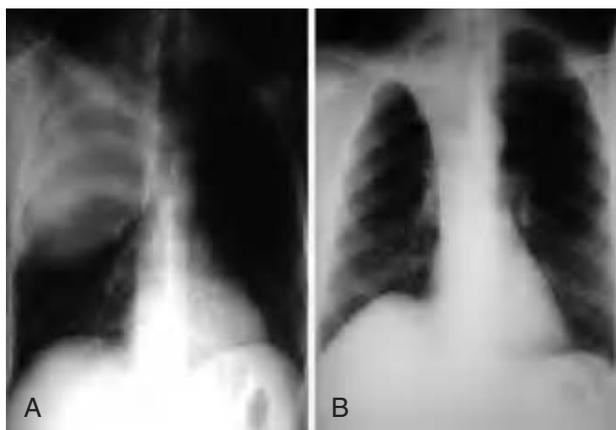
Chest radiograph showing a 15 cm mass (A) and radiograph of a tumor accompanied by atelectasia (B).
